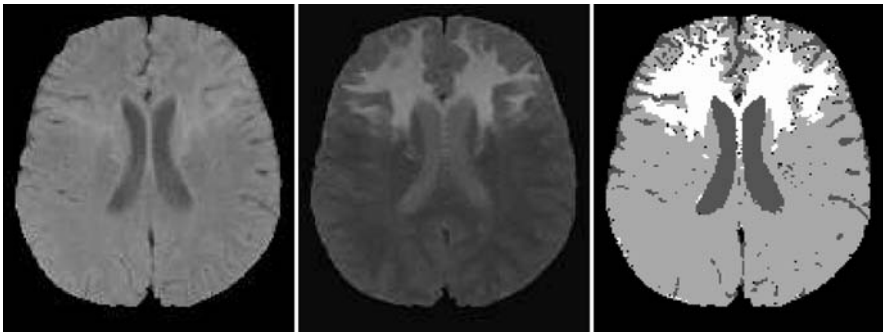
Dual echo MR image of the brain, showing three main classes: brain, ventricles, and pathology (the *white area* on the middle image). *Right*: final decision after fuzzy combination (note that the decision is taken at each pixel individually, without spatial regularization)
